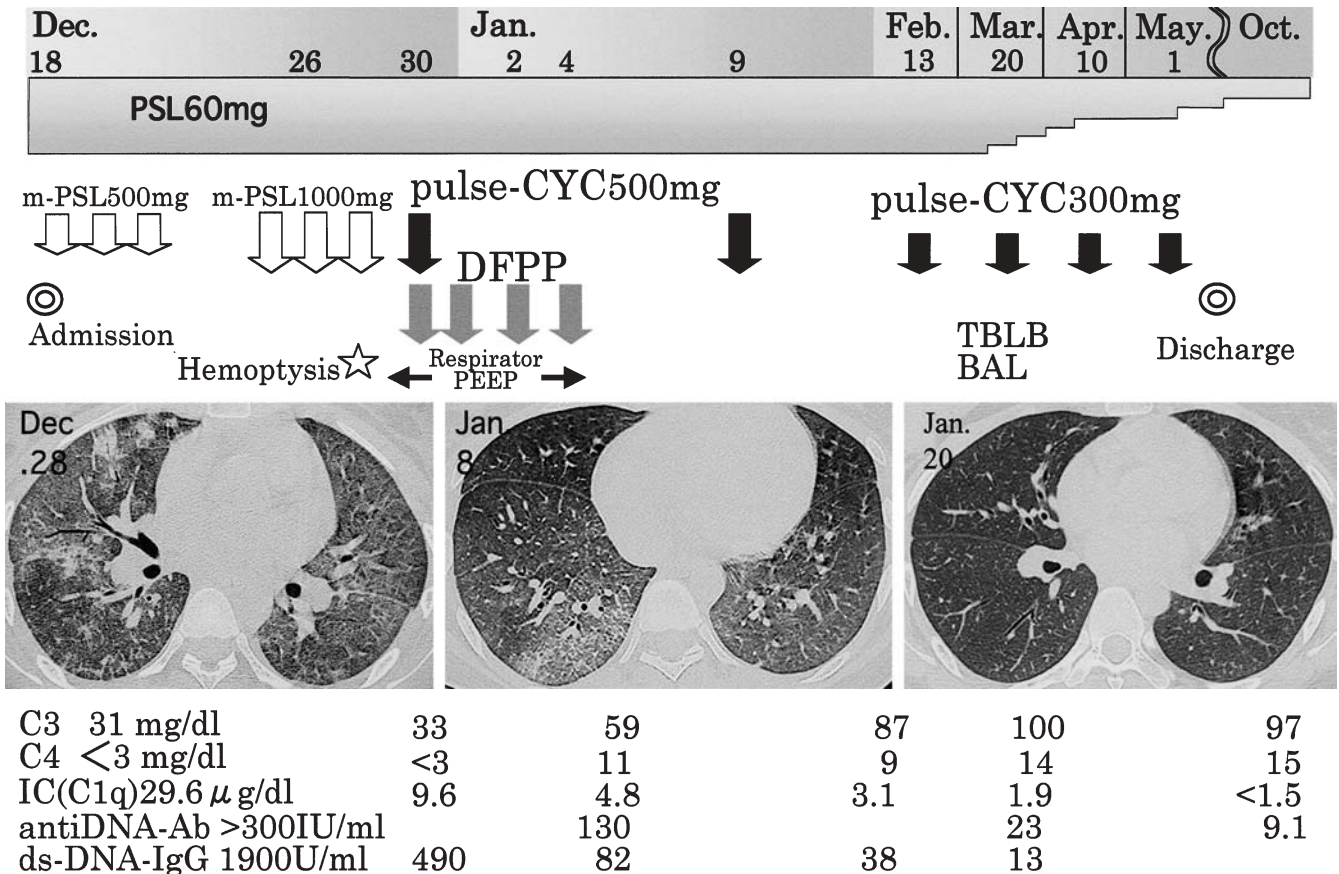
Course of treatment and progress from admission to discharge. Left Chest CT scan (December 28) that is the same as that in Fig. 3b. Center CT scan obtained after four double-filtration plasmapheresis (DFPP) treatments and one course of intravenous pulsed cyclophosphamide (CYC) (500mg) (January 8). Right CT scan obtained on January 20 after an additional pulse of cyclophosphamide (500mg).
